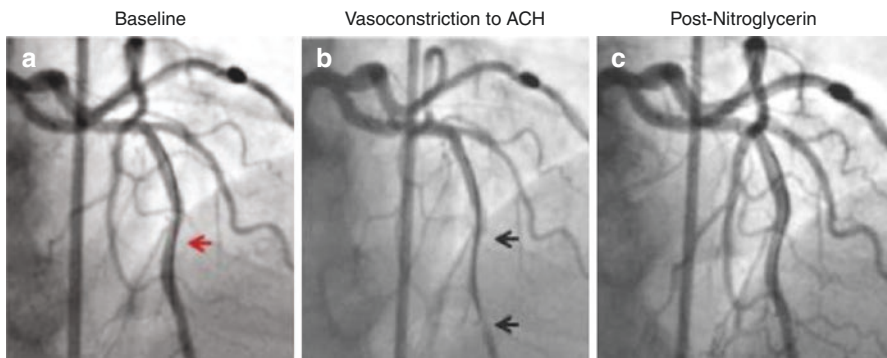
Coronary Angiogram and coronary reactivity testing. (a) The figure shows Doppler flow wire in the left anterior descending artery (red arrow). (b) In response to acetylcholine infusion, there is abnormal coronary artery vasoconstriction (black arrows), indicating endothelial dysfunction. (c) Resolution by intracoronary nitroglycerin (Wei, Mehta, Johnson, et al. Safety of coronary reactivity testing in women with no obstructive coronary artery disease. Results from the NHLBI-sponsored WISE study. *JACC: Cardiovascular Interventions*. 2012. 5(6): 646-652)
